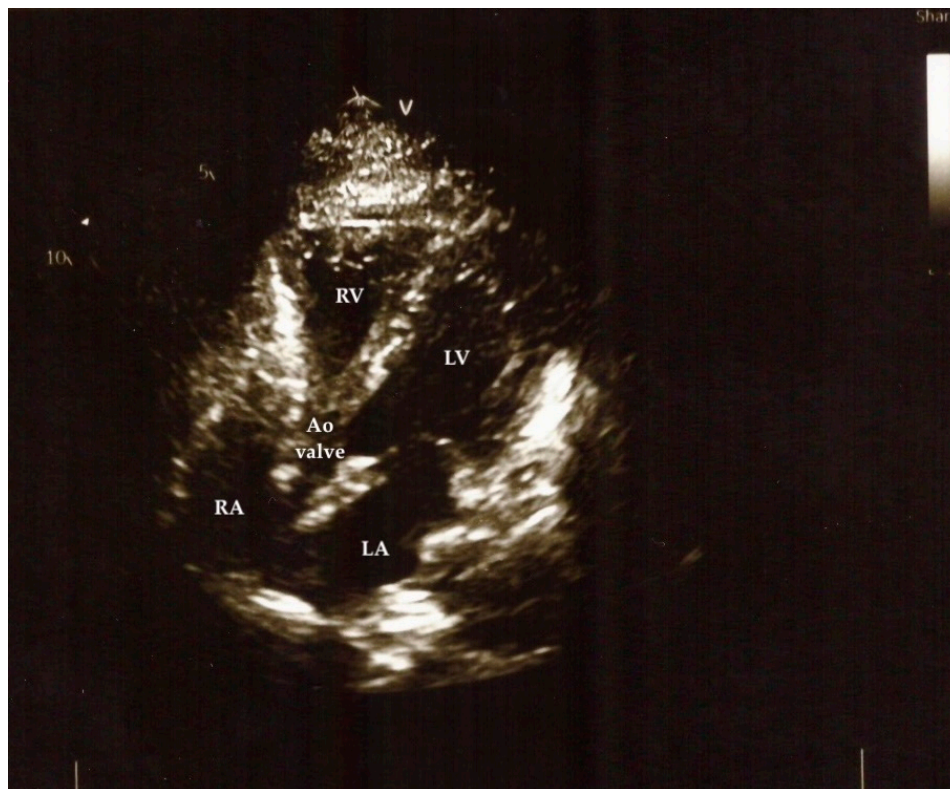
TTE of Clinical Case 1: An apical five-chamber view was the only view obtainable from the apical window and was of suboptimal quality despite maximal left lateral positioning of the transducer. Standard apical four-, two-, and three-chamber views could not be acquired. Ao – aortic; LA – left atrium; LV – left ventricle; RA – right atrium; RV – right ventricle.
